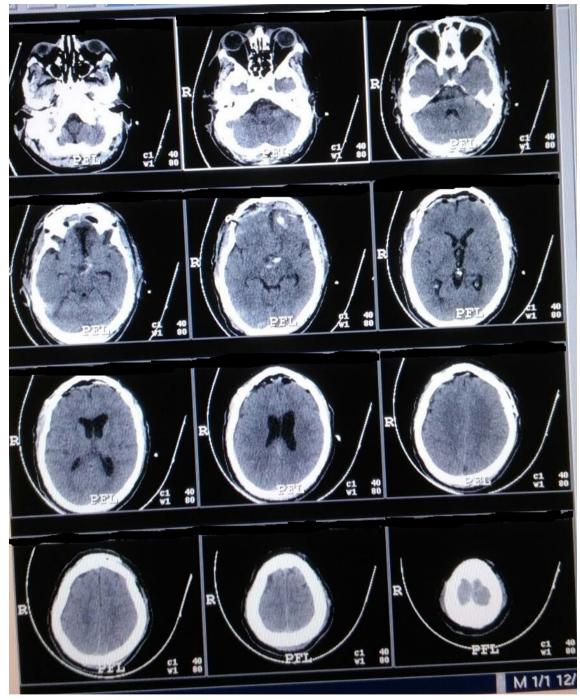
post-operative CT scan of patient 2
